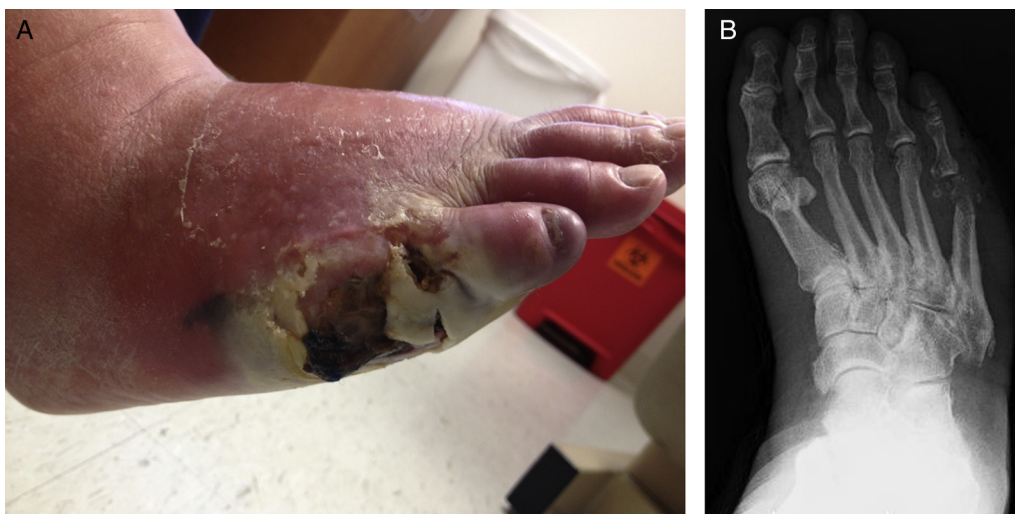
(A) Clinical photograph of a patient requiring emergency open transmetatarsal amputation because of gas gangrene. The procalcitonin value for this patient was 7.83 ng/mL; however, this patient subsequently healed despite the high value indicating that aggressive initial surgical intervention might be beneficial to patients with high procalcitonin values. (B) Corresponding plain film radiograph of this patient showing soft tissue emphysema diffusely throughout the forefoot.
